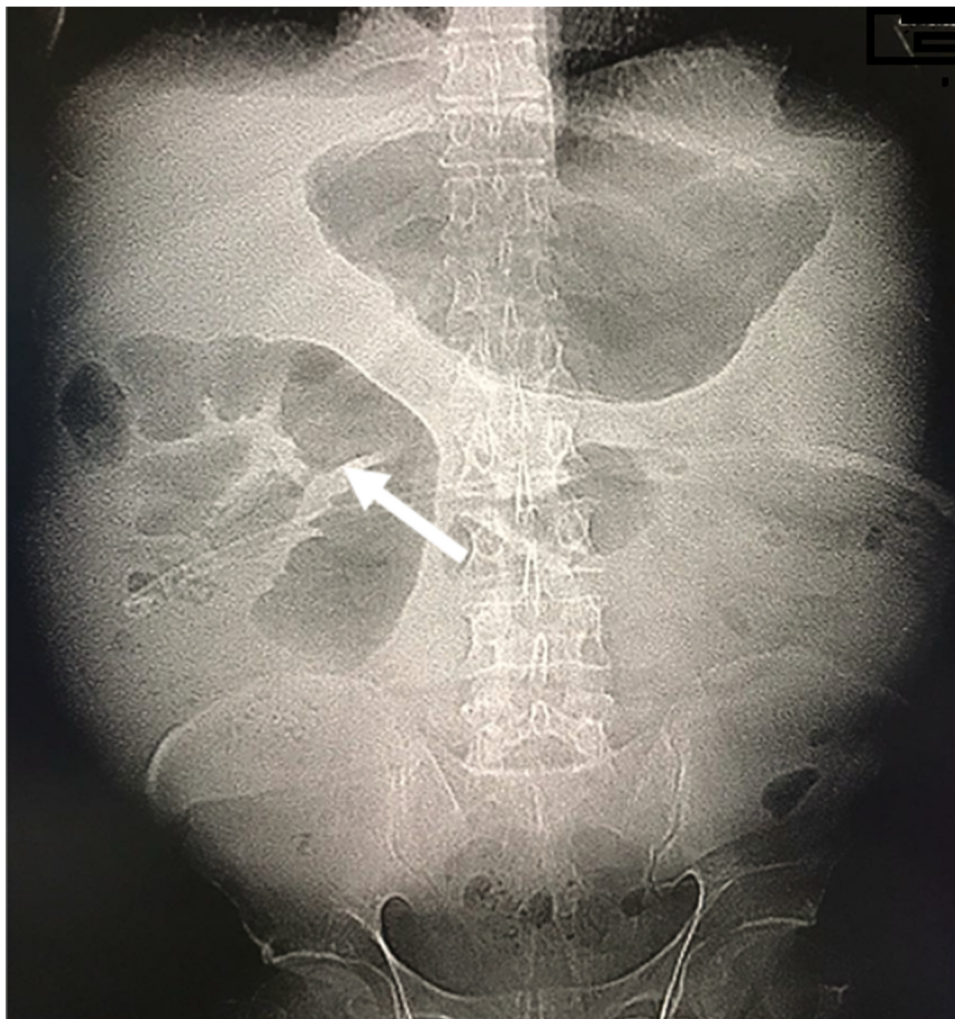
Plain abdominal radiograph (erect) showing fixed dilated small bowel loop in the right hypochondrial region (arrow).
